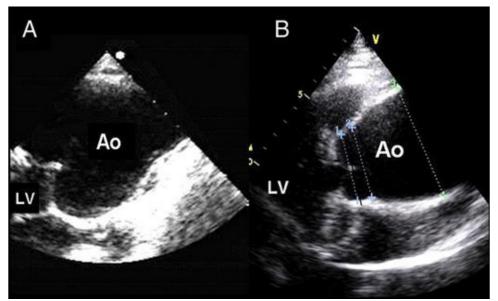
long-axis view by transthoracic echocardiography. (A) Annuloaortic ectasia with pyriform morphology. (B) Ascending aorta aneurysm located in the upper part of the sinotubular junction (Evangelista et al., 2019).
